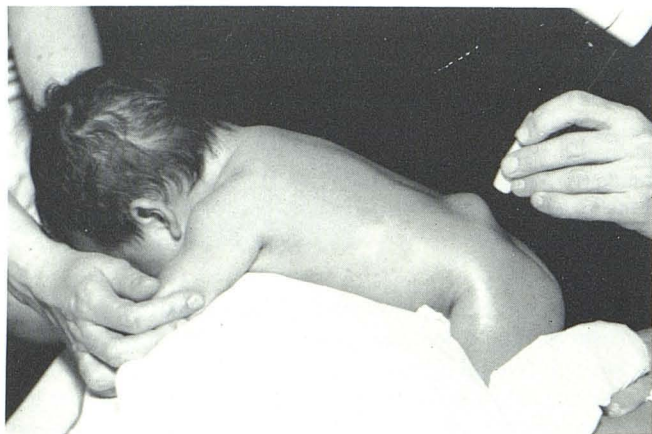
Patient position to distend caudal meningoceles for sonography. Throughout this article, all lateral and sagittal views are oriented with anterior to reader's left.
